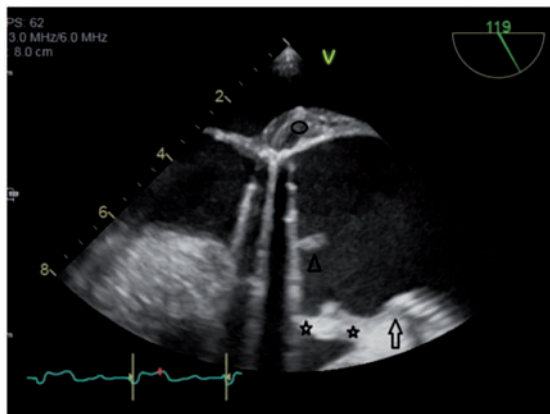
Initial transoesophageal echocardiogram demonstrating an uncertain aortic contour. Arrow—bottom end of tube graft. Stars—'2' sinuses of Valsalva. The one closest to the aortic valve proved to be a false aneurysm. Arrowhead—aortic valve vegetation. Oval—soft tissue aortic root thickening.
